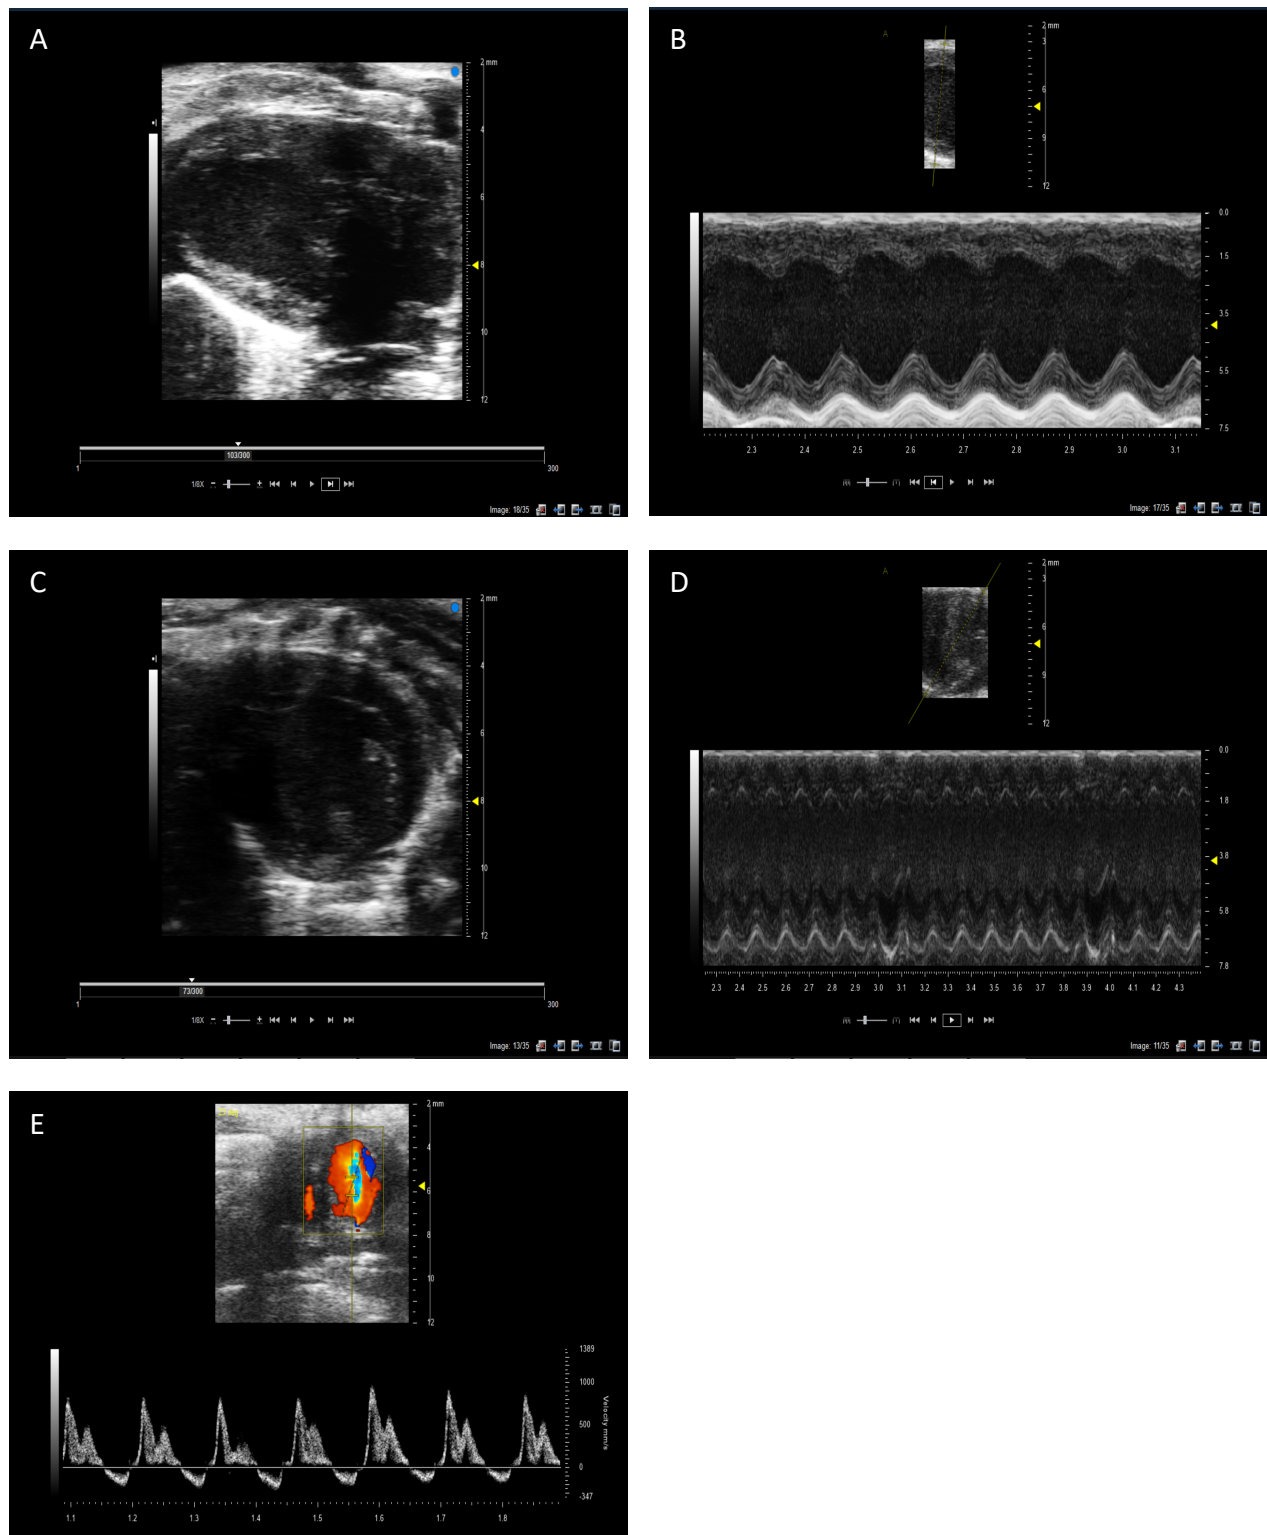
Exemplar echocardiograms.
